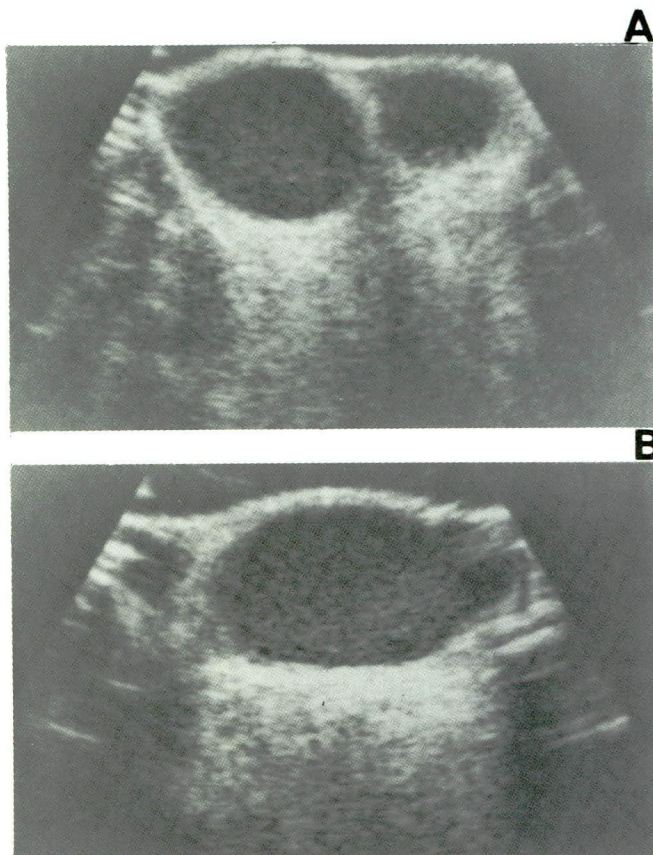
Testicular relapse in leukemia. A seven-year-old with history of acute lymphoblastic leukemia in remission, presenting with bilaterally enlarged testicles. Transverse (A) and sagittal (B) sonograms show asymmetrically enlarged and diffusely hypoechoic testicles.
